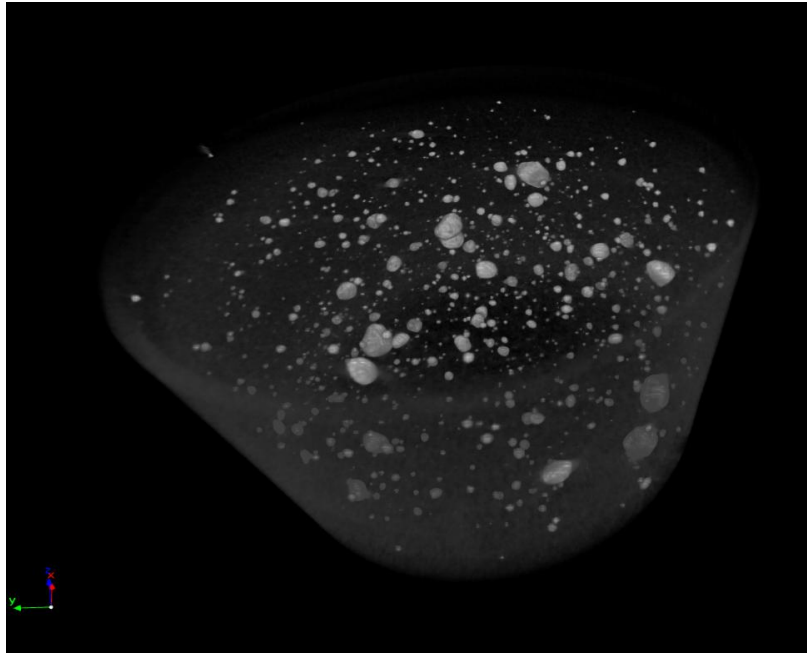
Volume rendering of X ray CT of agglomerates in a sample prior to with intensifier bar blending.
